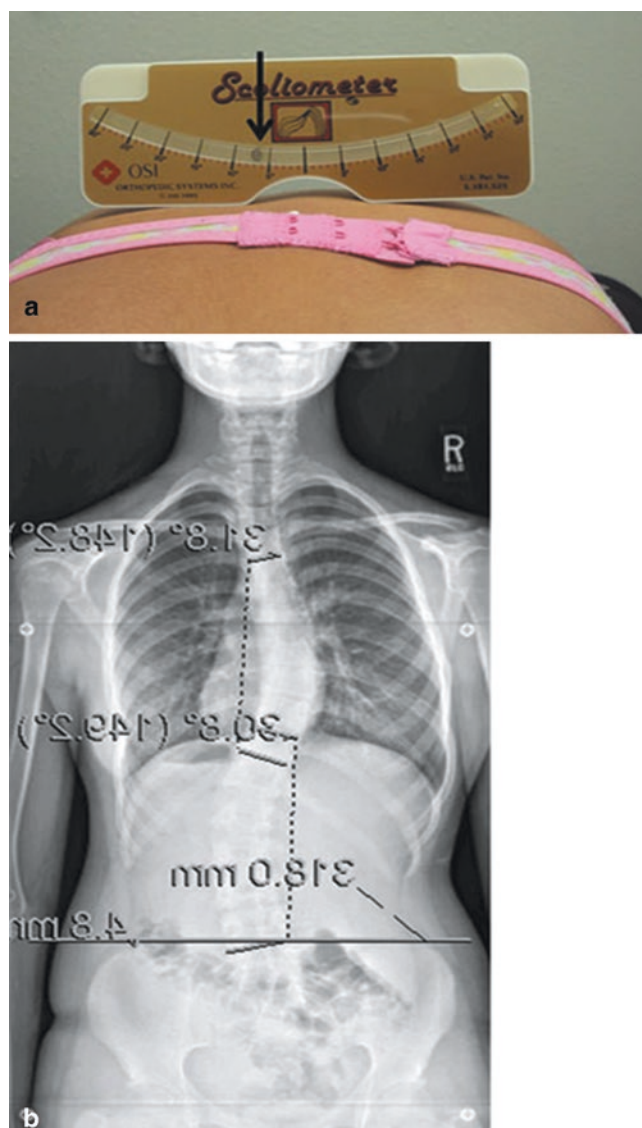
Scoliometer. A 14-year-old girl with adolescent idiopathic scoliosis. (a) Scoliometer shows 7° of asymmetry (arrow). (b) Radiograph shows 31° at mid thoracic level
